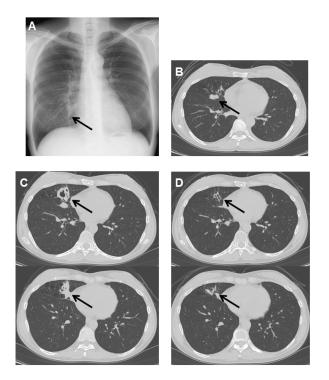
Chest X-ray and computed tomography findings in case 2. Two weeks after the initiation of remission induction therapy for systemic lupus erythematosus (SLE), chest X-rays (A) and computed tomography (CT) (B) revealed nodules in the middle right lung lobe (indicated by arrows). One month after the first chest CT scan, a second chest CT scan showed that the nodules had enlarged and formed a cavity (C) (indicated by arrows). After 6 weeks of treatment for nocardiosis, a chest CT scan (D) revealed that the cavity (indicated by arrows) was less opaque. (A) A chest X-ray 2 weeks after initiation of remission induction therapy. (B) Chest CT scan 2 weeks after initiation of remission induction therapy. (C) Chest CT scan 1 month after the first chest CT scan. (D) Chest CT scan after 6 weeks of treatment for nocardiosis.
